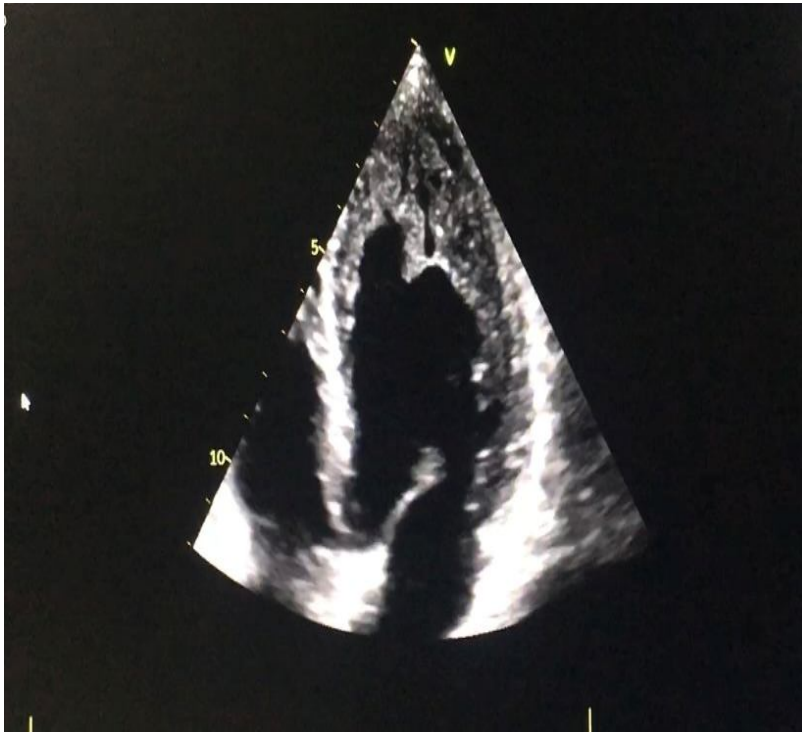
apical 4-chamber echocardiographic section showing a trabeculated aspect of the apex of the left ventricle
